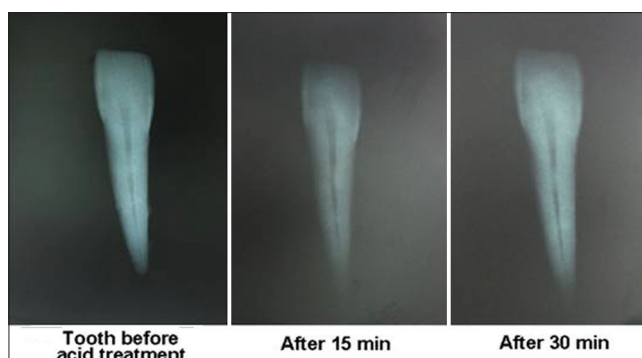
Radiographical appearance of teeth treated with conc. H_2SO_4 at different interval
